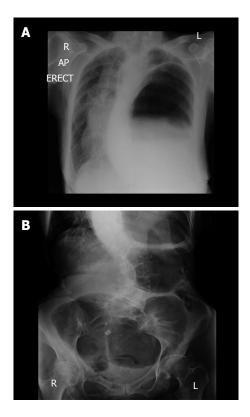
Plain radiographic images of the patient upon emergency admission. A: Erect chest radiograph upon admission demonstrated that the patient had a collapsed left lung and elevated left hemidiaphragm with a large viscous identified under the left hemidiaphragm; B: Plain abdominal radiograph on admission revealed a gas filled viscous within the left upper quadrant consistent with caecal volvulus.
